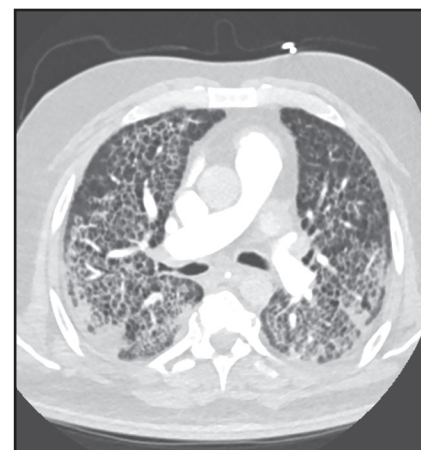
A 53-year-old man with history of tobacco use. (A) Axial CT image demonstrates centrilobular and paraseptal emphysema in the right upper lobe. (B) Axial CT image of the same patient 8 months later shows post-operative appearance after aggressive fluid resuscitation and consequent pulmonary edema producing a Sponge Lung appearance.
